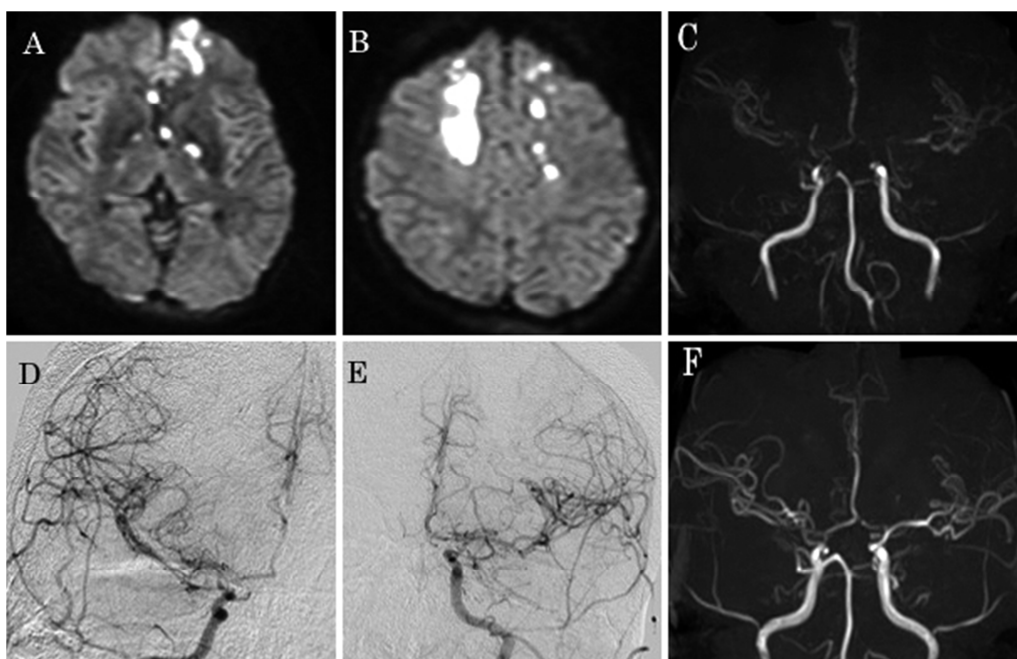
Magnetic resonance (MR) assessments for the patient. Diffusion-weighted MR images show acute ischemic lesions (A, B). MR angiography at the time of presentation to neurosurgery revealed distal and bilateral stenosis of the internal carotid artery (ICA) and middle cerebral artery (MCA) (C). On the left (D) and right (E) cerebral angiography, moderate stenosis was identified in bilateral distal ICA and MCA. In MR angiography 7 weeks after admission, stenosis of bilateral ICA and MCA considerably improved (F).
